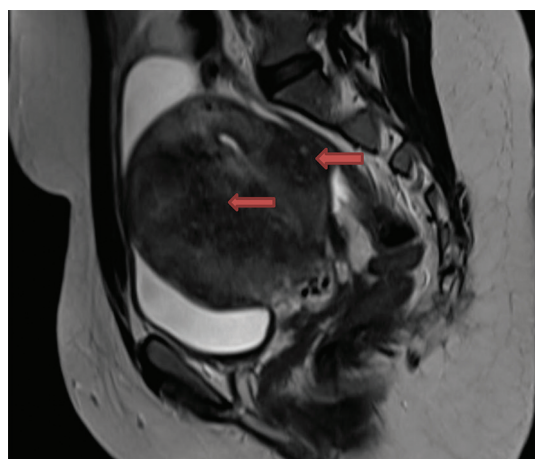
T2 weighted sagittal section of MRI of pelvis of a 32 year old reveals diffusely bulky uterus. Anterior myometrium appears bulky in thickness and heterogeneous in signal intensity. Ill-defined varying signal with vague borders seen in the anterior myometrium – suggestive of adenomyosis with few hyperintense foci embedded within the lesion – likely hemorrhagic foci. Smaller similar signals were seen in the posterior segment – likely smaller adenomyomas.
